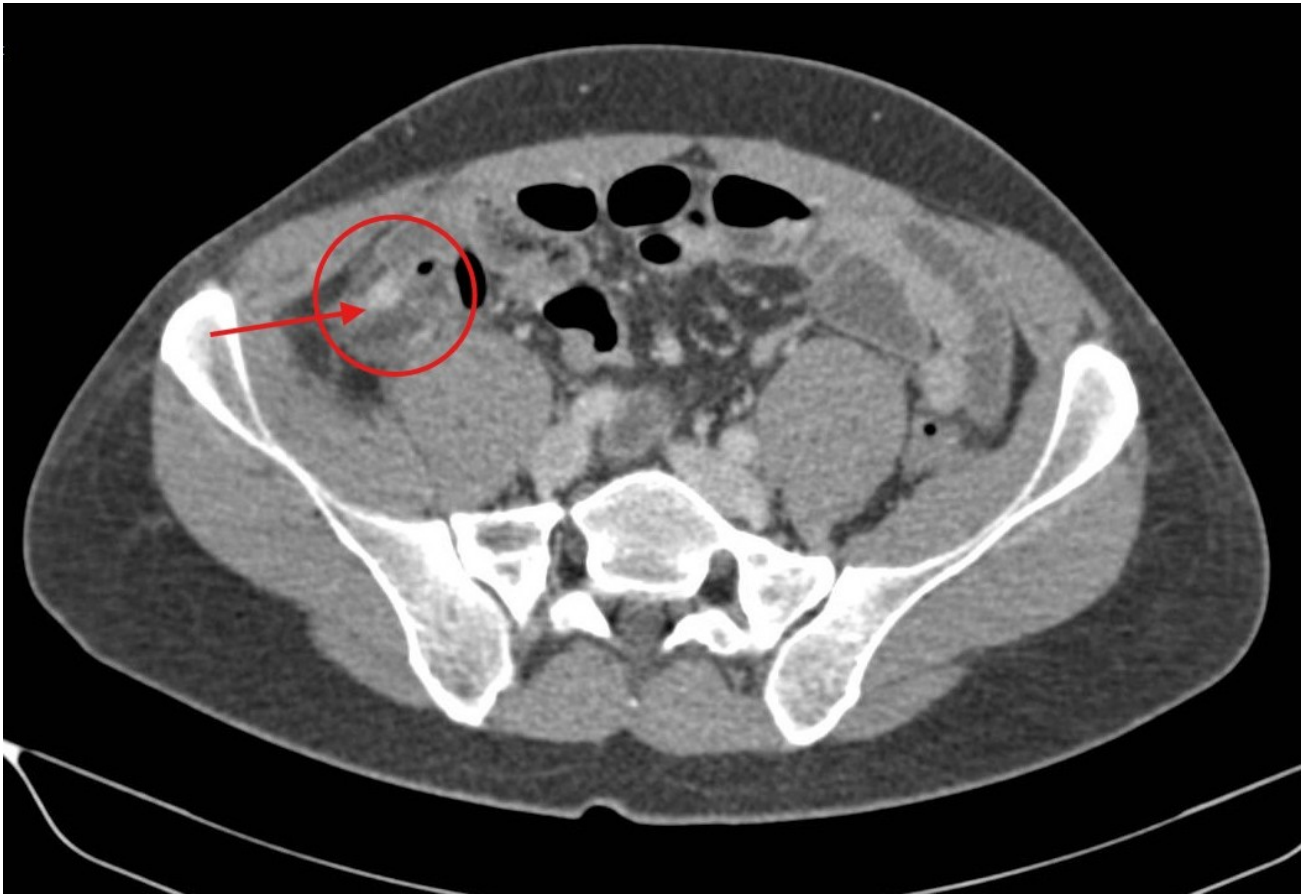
Contrast-enhanced CT scan. The red arrow indicates appendiceal distension with wall thickening and appendicoliths, while the red circle highlights associated periappendiceal fluid collection.
